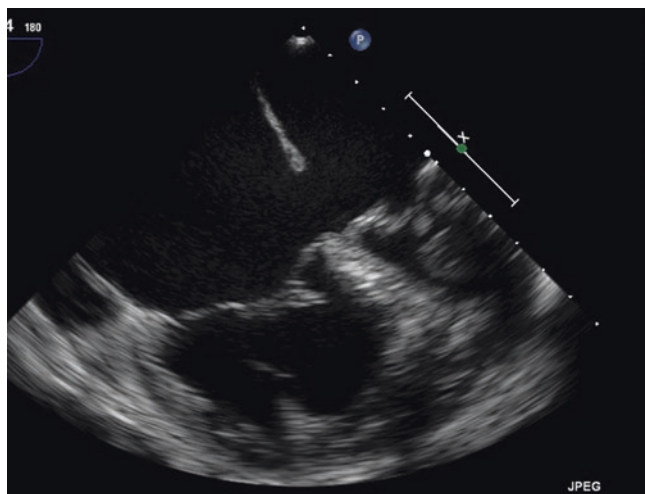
Trans-esophageal echocardiogram view of a moderate primum atrial septal defect
